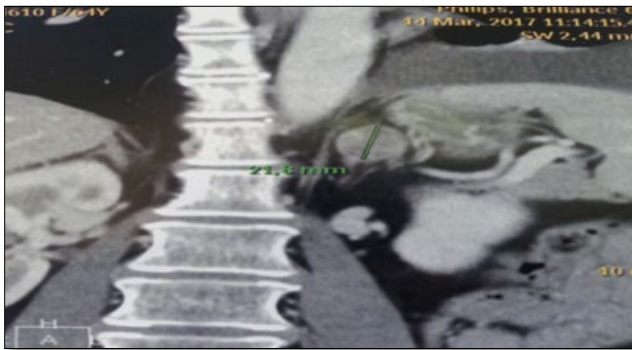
CT scan of case 1 demonstrating an enlarged heterogeneous left adrenal gland.
